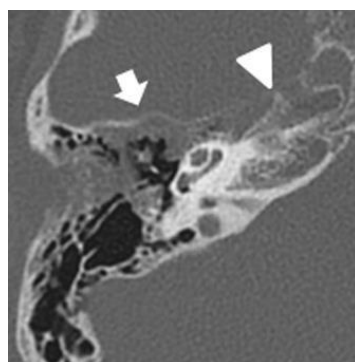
Non-contrast axial CT of the temporal bone, showing partially lytic lesion in the right mastoid air cell (arrow) and petrous apex (arrow head). Note fluid in the mastoid air cells and at the apex of the petrous temporal bone.
